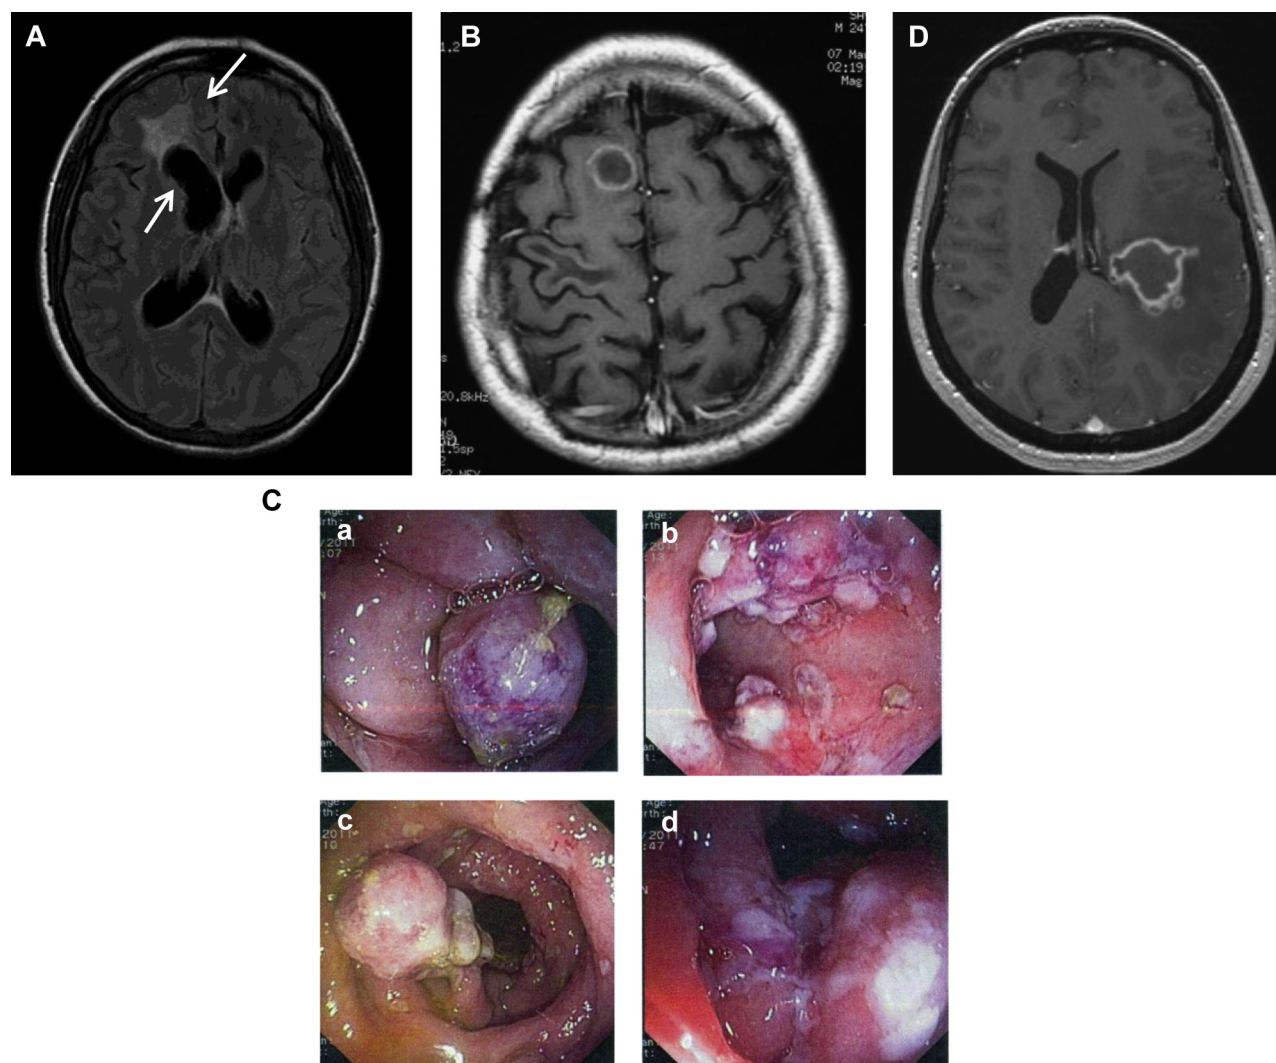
Clinical, pathologic, and radiologic features of patients. A and B, Brain abscess of P1 (Fig 2, A) and brain CT scan of P3 (Fig 2, B). C, a-d, Colonoscopy results for P3. D, Brain MRI of P4.
